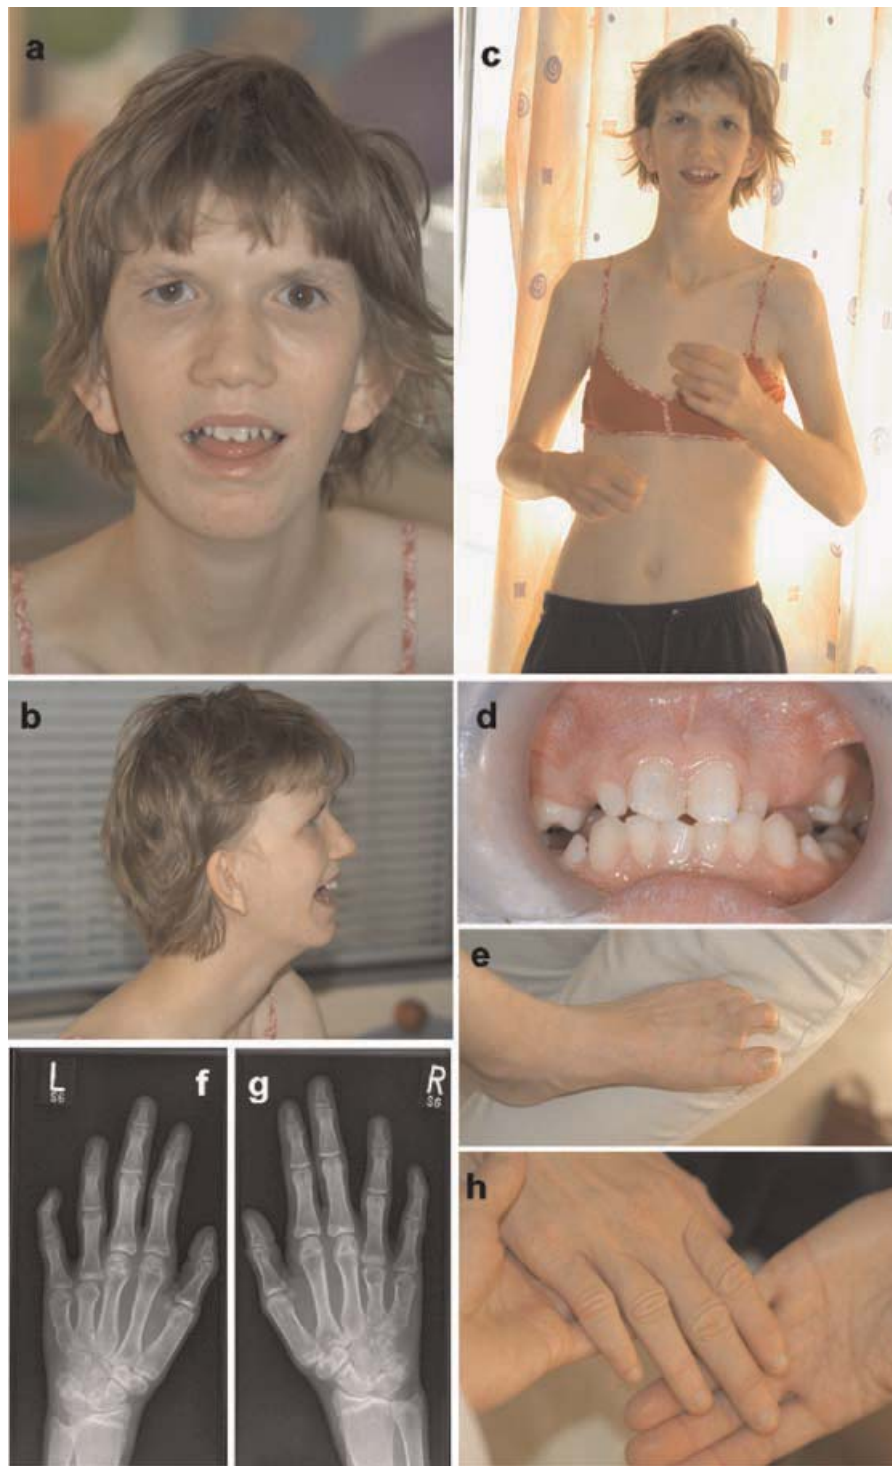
Phenotype of the girl at age 15 years. a,b: Facial appearance: note brachycephaly, deep-set eyes with downslanting palpebral fissures, ptosis and prominent supraorbital ridges, broad nose, large mouth with open-mouth appearance, large and deep-set ears with overfolded helices. c: Thoracic asymmetry, contractures of elbows, thin and tall aspect. d: Mishaped teeth and oligodontia. e: Claw toes. f-h: X-rays and photographs of hands, note shortened phalanges IV and V, and wrinkled skin. [Color figure can be viewed in the online issue, which is available at www.interscience.wiley.com.]
